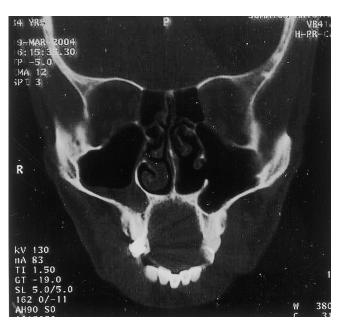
Postoperative CT. The left maxillary sinus is well ventilated, the orbital volume has been restored and the orbital contents are in their normal position.
